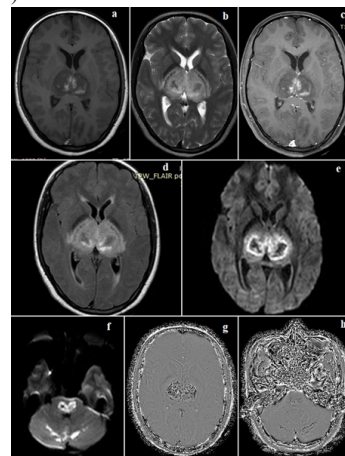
MRI Brain a.T1W-SE; b. T2W-TSE; c. T1W-SE Post contrast; d. T2W-FLAIR post contrast; e, f. DWI; g,h. SWI. (Description in text.)
